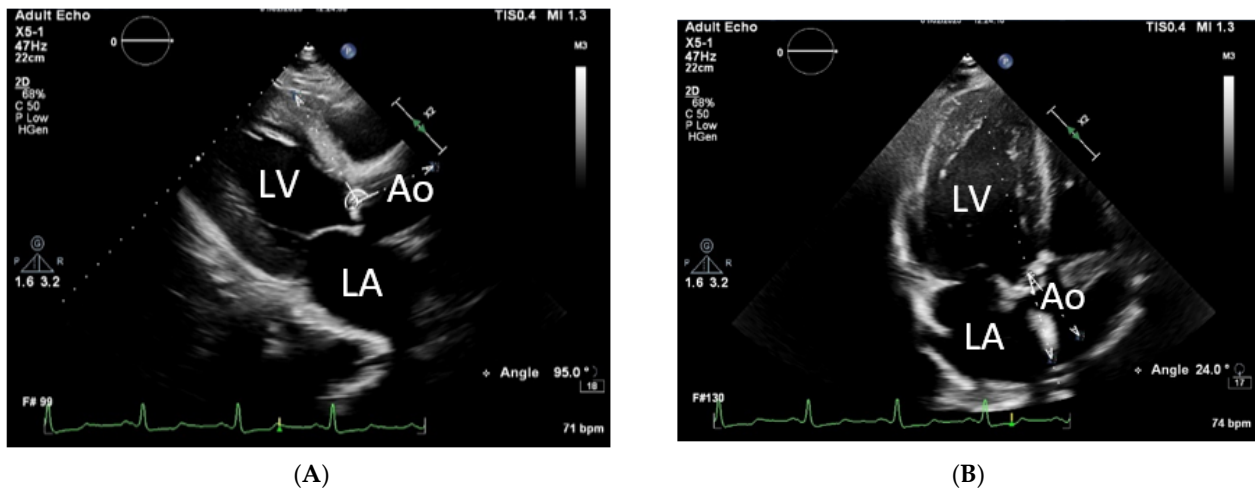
(A) Left ventricular long-axis view, aortic root angulation (the aortoseptal angle is 95°); (B) apical 5-chamber view (the Doppler transaortic flow intercept angle is 24°). The left ventricle (LV), left atrium (LA), and ascending aorta (Ao) are registered.
